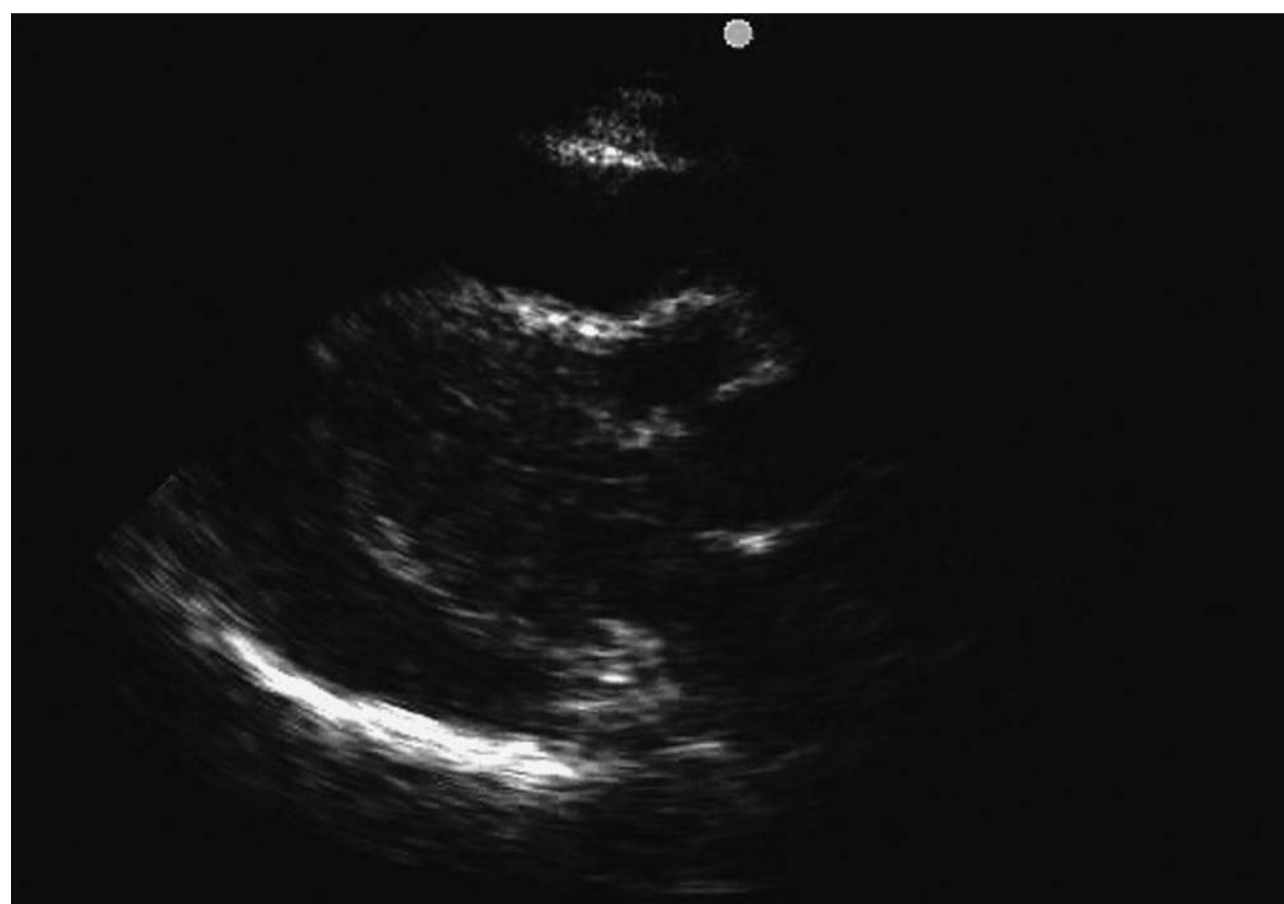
Parasternal long-axis view showing right ventricular collapse in the setting of a large pericardial effusion. The elevated pericardial pressure is causing right ventricular collapse during diastole, consistent with tamponade physiology.
